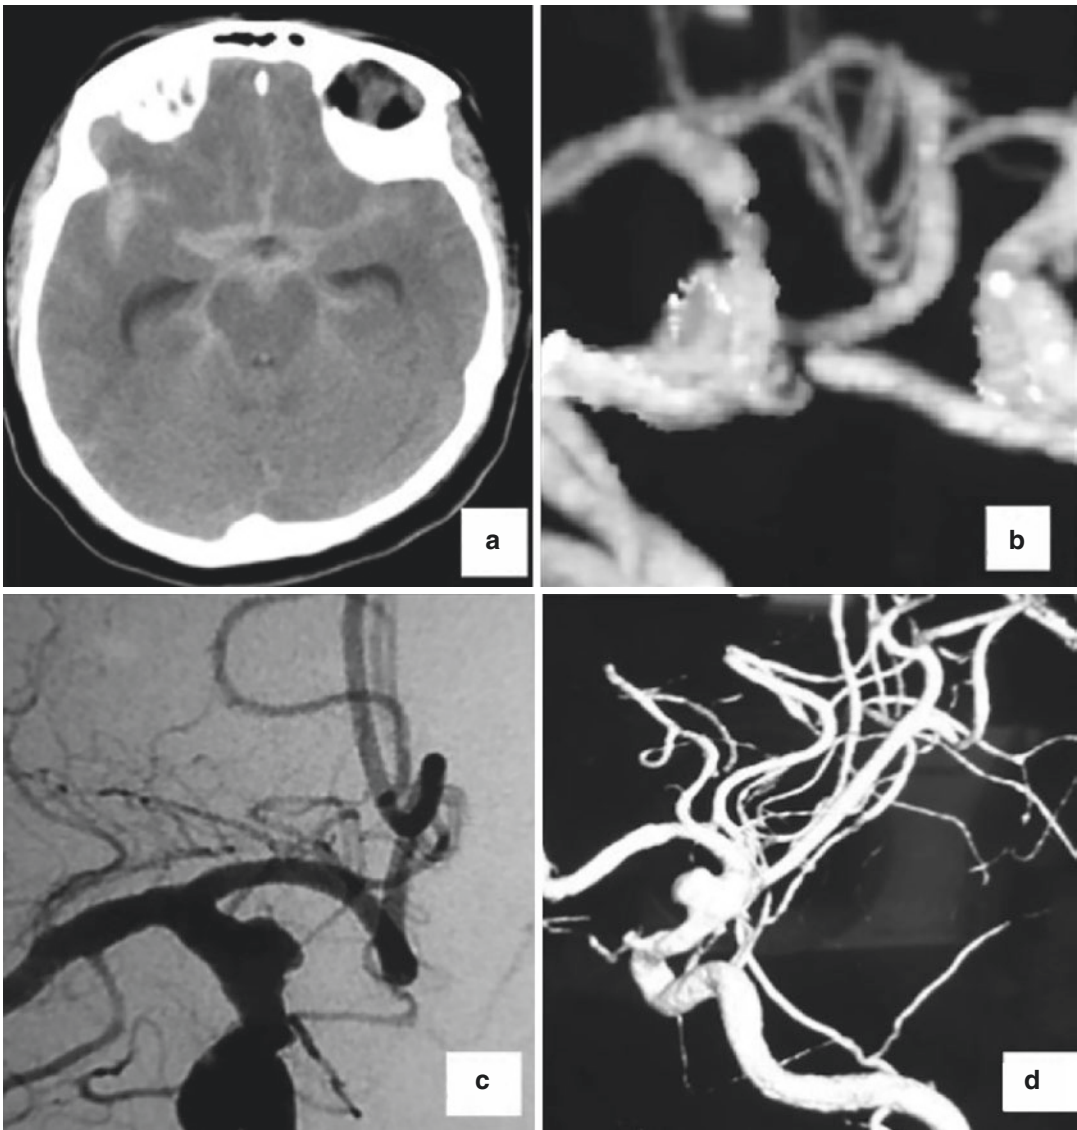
(a) Shows CT brain plain shows WFNS grade IV SAH. (b) Shows CTA negative for aneurysm. (c, d) Showing angiogram with a blood blister aneurysm
